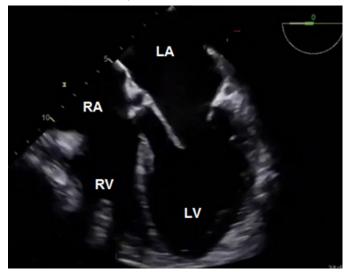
Transesophageal echocardiography. Midesophageal view at 0 degrees. All 4 chambers are visible.
